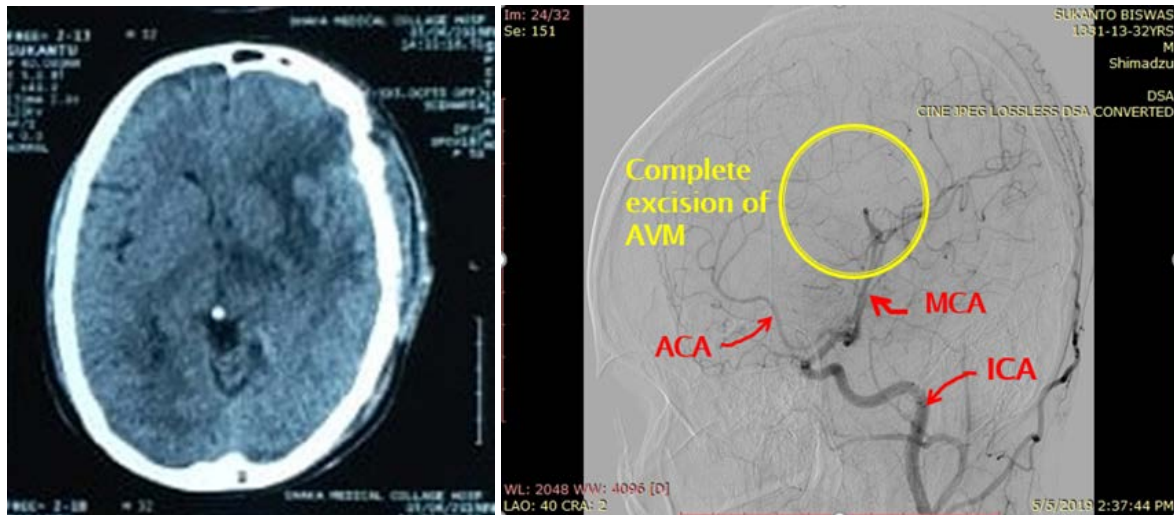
Post-operative CT scan of brain (J) and cerebral DSA (K) showing complete removal of the AVM.
